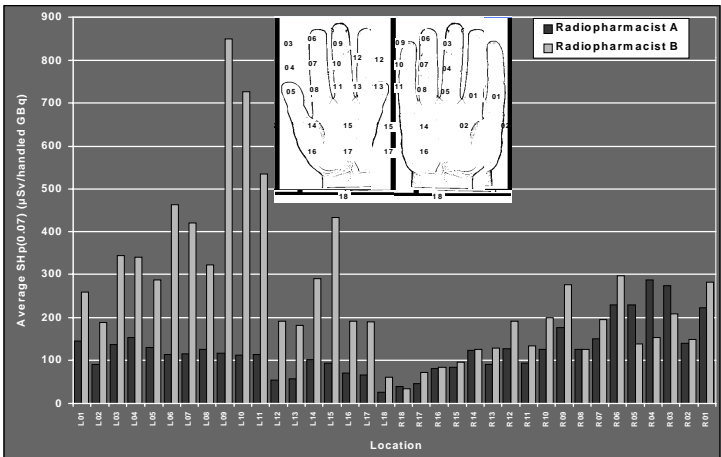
SHp(0.07) at 36 locations on the hand during dispensing of  $^{18}\text{F}$ FDG
